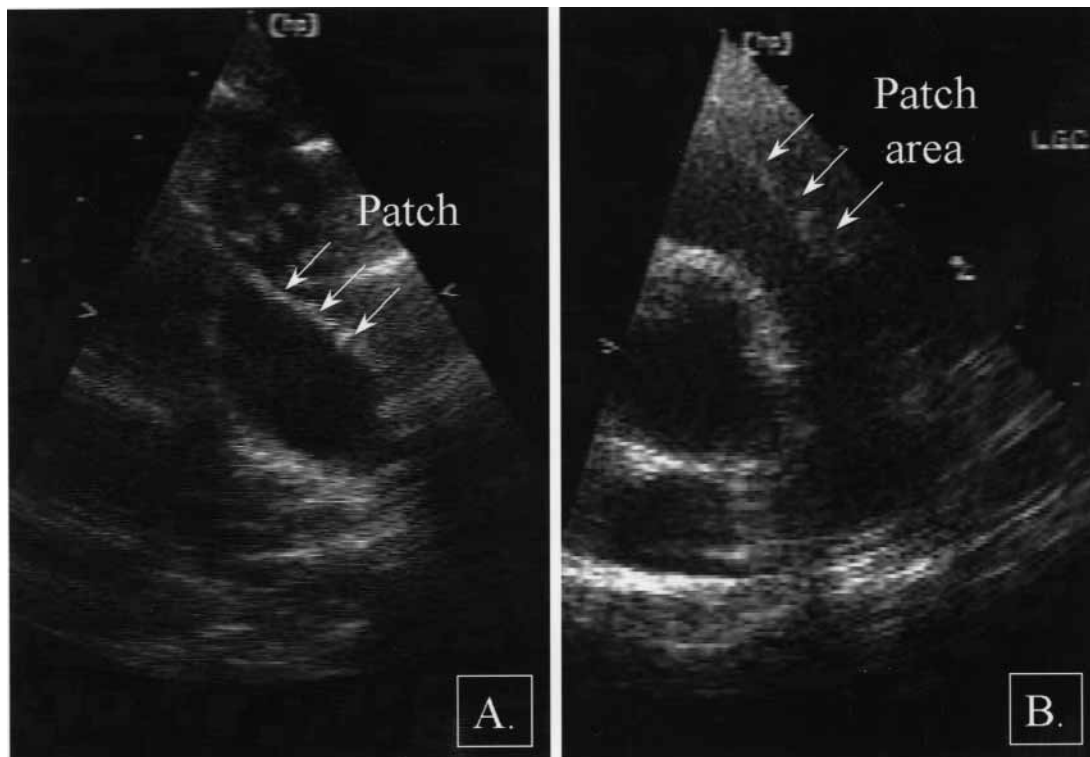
Echocardiographic assessment. A, Long axis after 1 week of implantation. Enhanced echocardiographic density of patch material. B, Long axis after 26 weeks of implantation. Patch area is undistinguishable from native pulmonary artery.
